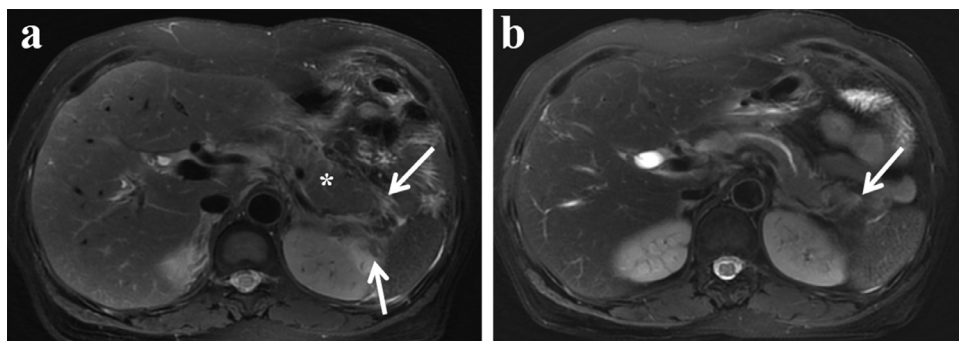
Interstitial edematous pancreatitis with APFC in a 53-year-old woman. (a) Axial fat-saturated T2-weighted MR image on the first day of onset reveals extrapancreatic fluid and stranding around the tail of the pancreas and the left anterior pararenal space (white arrows), with a normal-appearing pancreatic parenchyma (*). (b) Axial fat-saturated T2-weighted MR imaging 10 days later shows that the extrapancreatic collections were basically absorbed.
